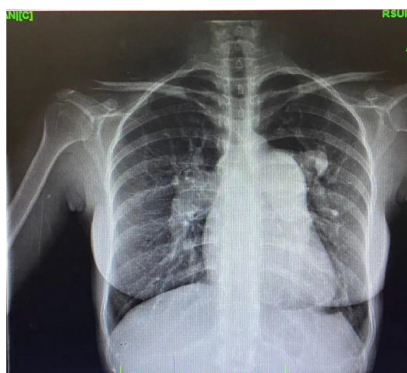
Chest x-ray showed pulmonal hypertension.
